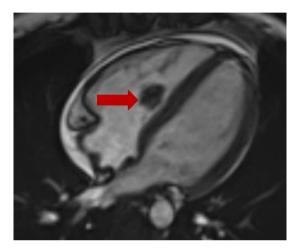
Cardiac MRI demonstrates a large multilobulated mass within the right ventricle with tissue characterization most consistent with thrombus.
